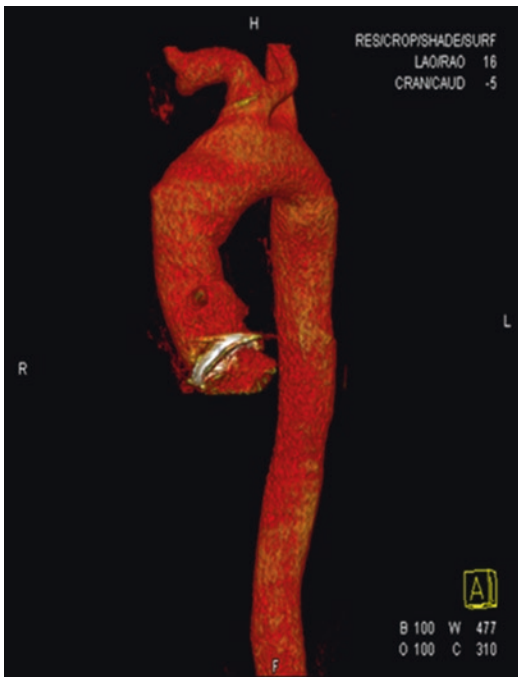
CT angiography of the thoracic aorta after treatment
